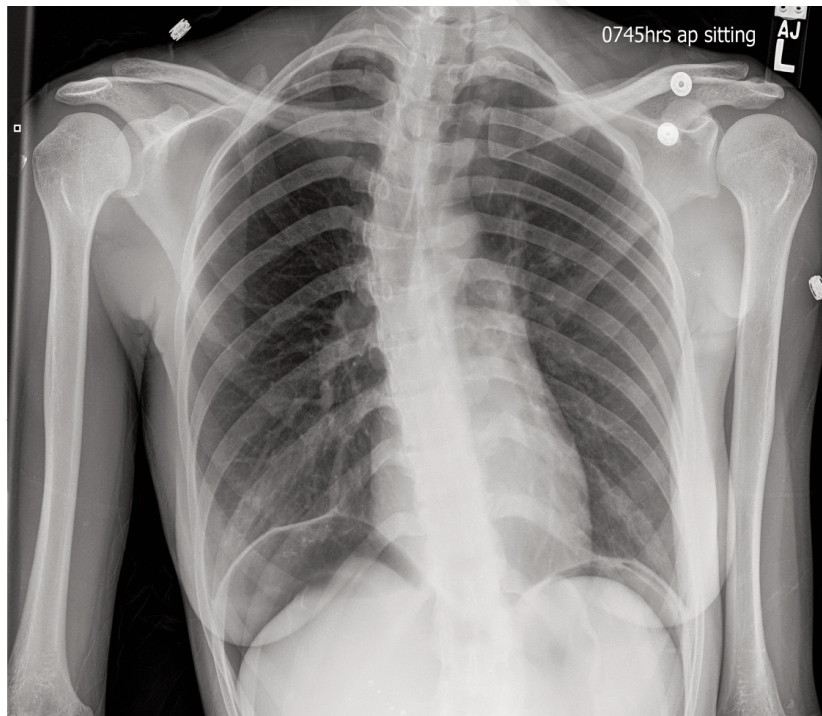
Upright anterior-posterior upright chest X-ray of a 22-year-old, sexually active, female demonstrating suspected pneumoperitoneum.
